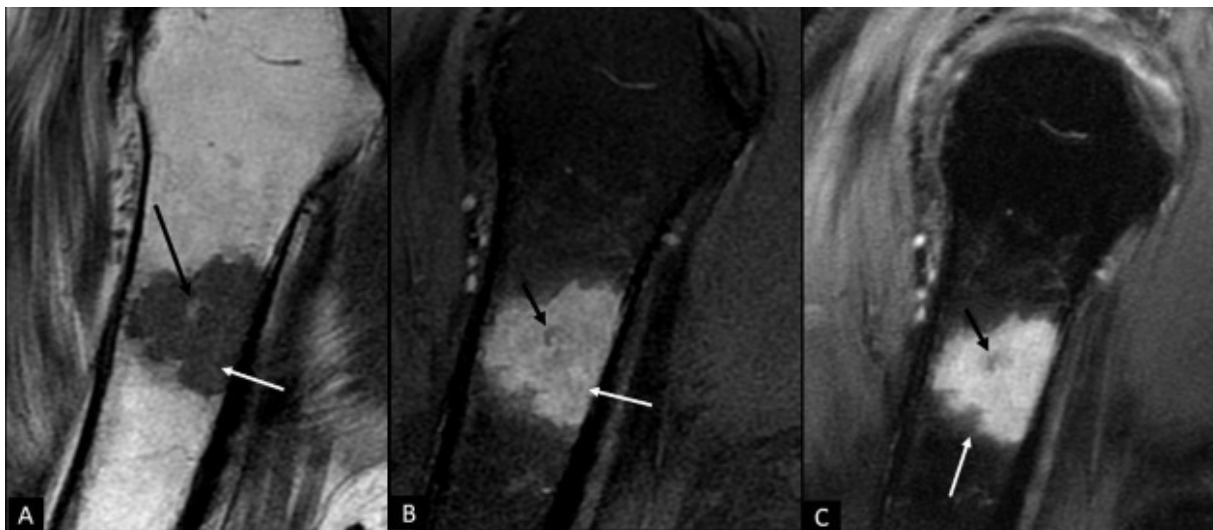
Sagittal (A) T1 weighted and (B) PD fat saturated MR images of the shoulder. With the proximal humeral diaphysis, there is a well-defined intramedullary lesion, which is hypointense on the T1 weighted image and hyperintense on the PD fat saturated image (white arrow) with intrinsic T1 hyperintense signal and corresponding low signal on fat-saturated image consistent with intralesional fat (black arrow). There is no perilesional edema, cortical destruction, or extraosseous soft tissue component. (C) T1 weighted post contrast fat saturated image demonstrates diffuse enhancement (white arrow).
